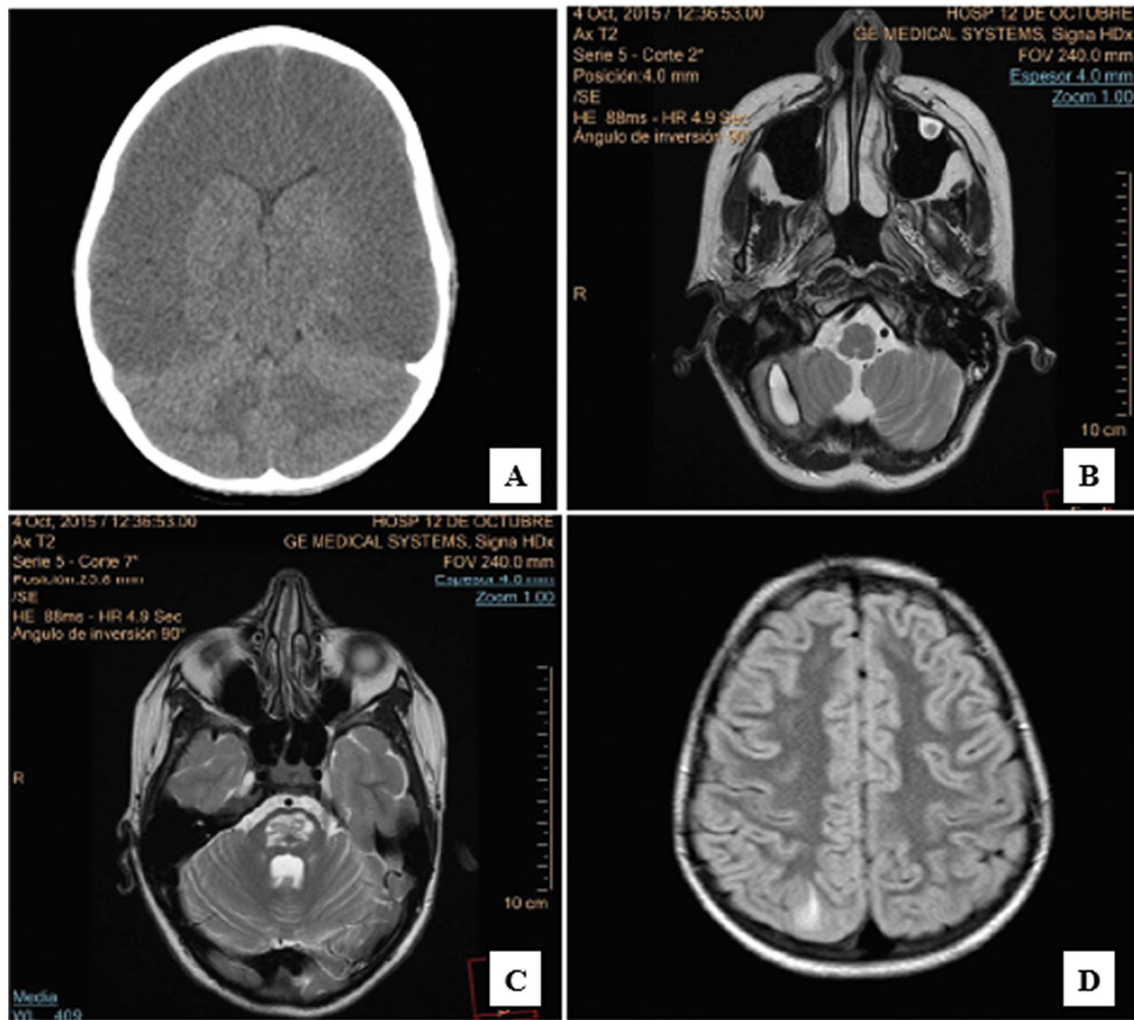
A) Non-contrast cranial CT: diffuse parenchymal hypoattenuation, loss of cortico-subcortical differentiation, and collapse of the ventricular system, compatible with diffuse cerebral oedema. B) Brain MRI (T2-weighted, axial plane): oval hyperintensity with a hypointense halo in the right cerebellar hemisphere, compatible with haematoma. C) Brain MRI (T2-weighted, axial plane): hyperintensity affecting nearly the entire central region of the pons, suggestive of central pontine myelinolysis. D) Brain MRI (FLAIR, axial plane): patchy hyperintensities in the juxtacortical and subcortical white matter of the parieto-occipital region of the right hemisphere.
